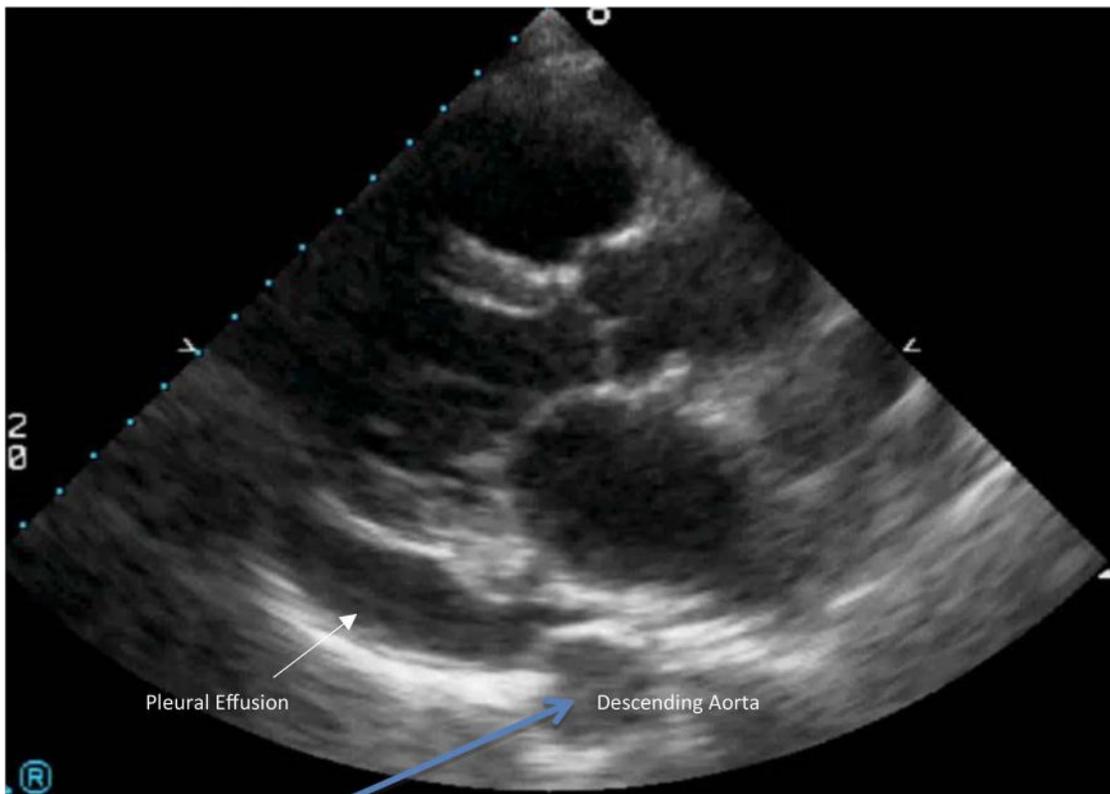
Parasternal long-axis (PLAX) with pleural effusion.
